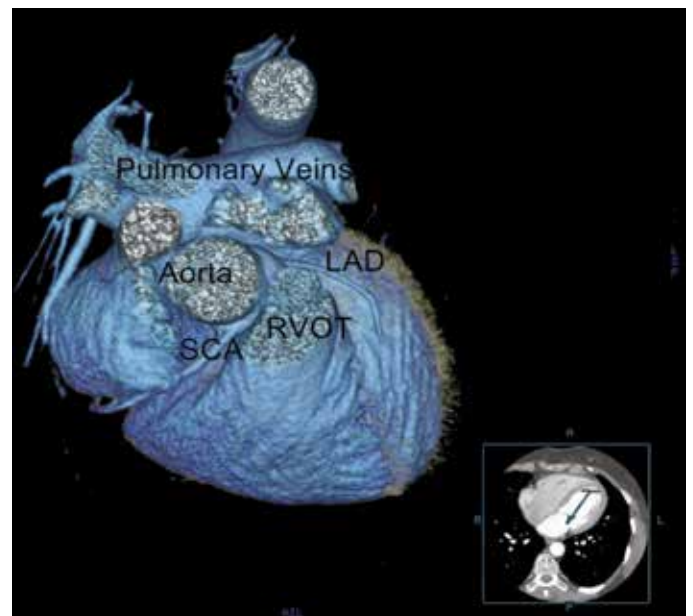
Multislice CT demonstrating the retroaortic take off single coronary artery
